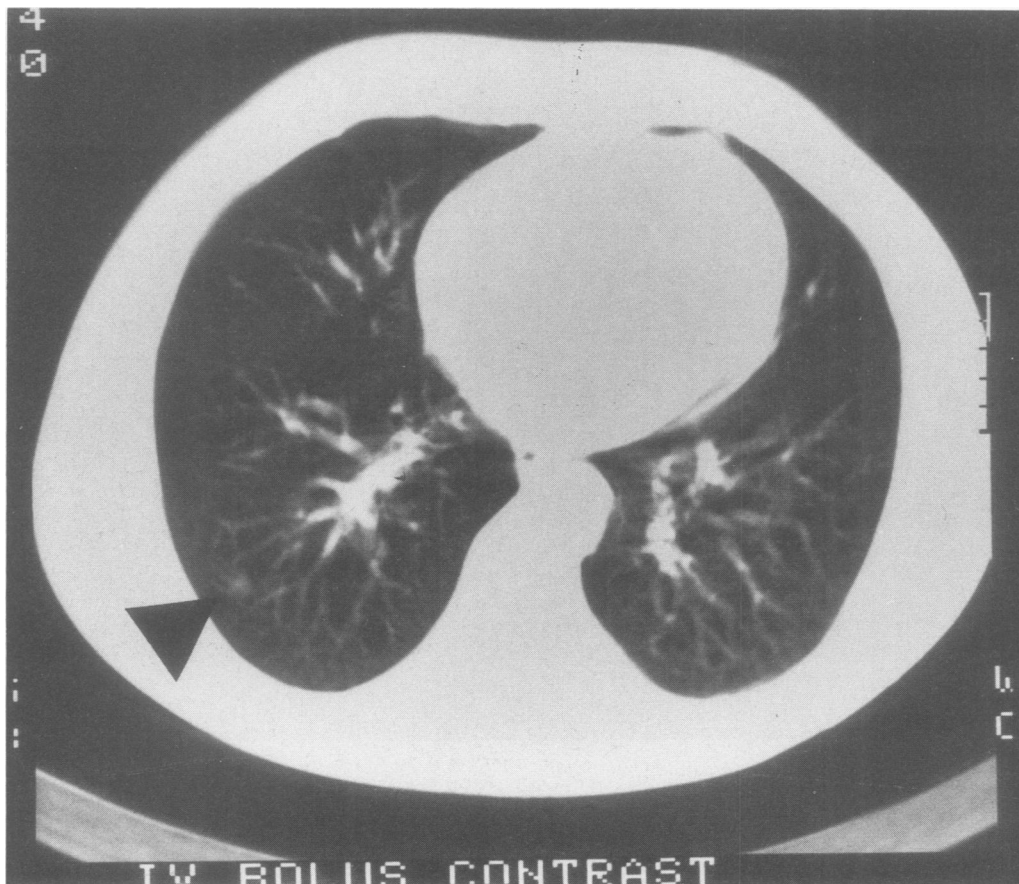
Chest computed tomograph, lung windows, indicating presence of a 1-cm sarcoma peripheral lung metastasis not seen on plain chest x-ray.
